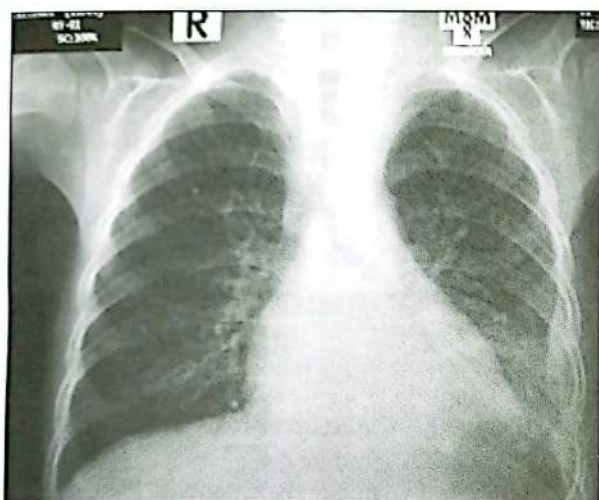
Follow-up X-Ray chest P/A view showing heart and mediastinal shadow normal.
